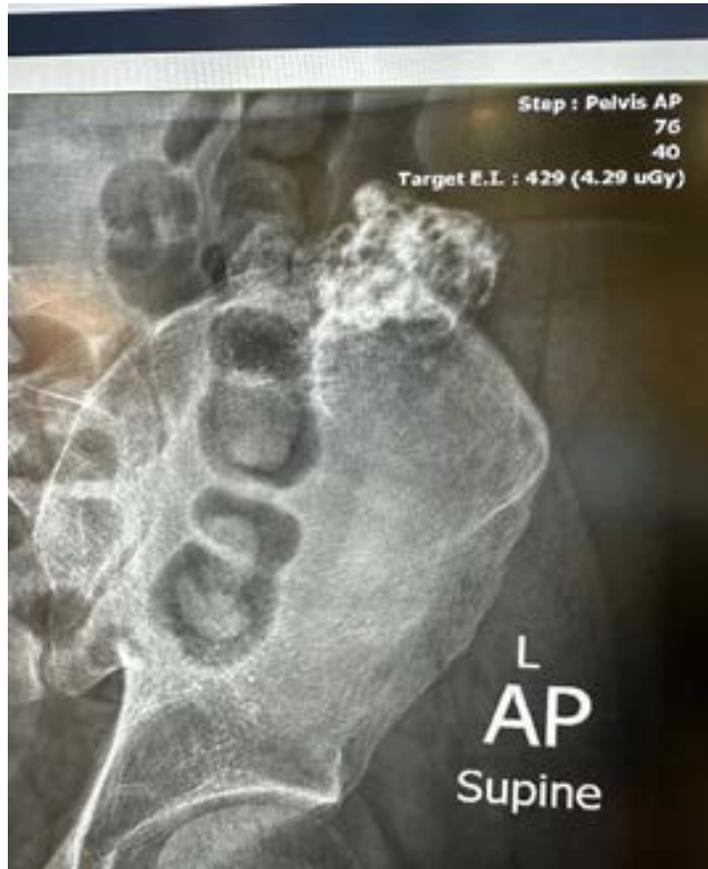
Radiograph of a large osteochondroma of the left iliac wing.
